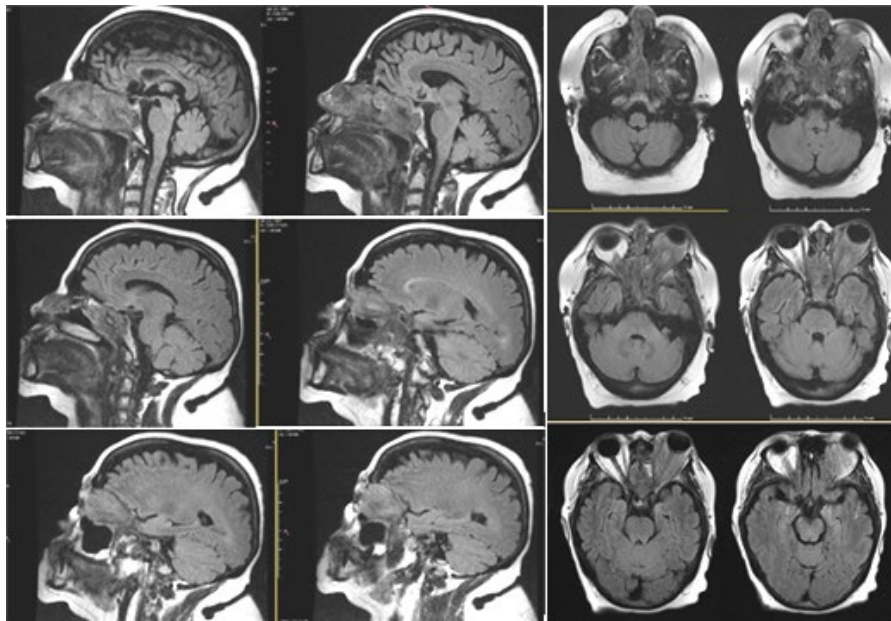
MRI/January 2022-Sag T2 FLAIR and AxT2 FLAIR visualizes a soft tissue tumor engaging bilateral the sphenoid sinus and ethmoidal sinuses, which destroys the adjacent bones and enters the two nasal passages and infiltrates the left retrobulbar space.
